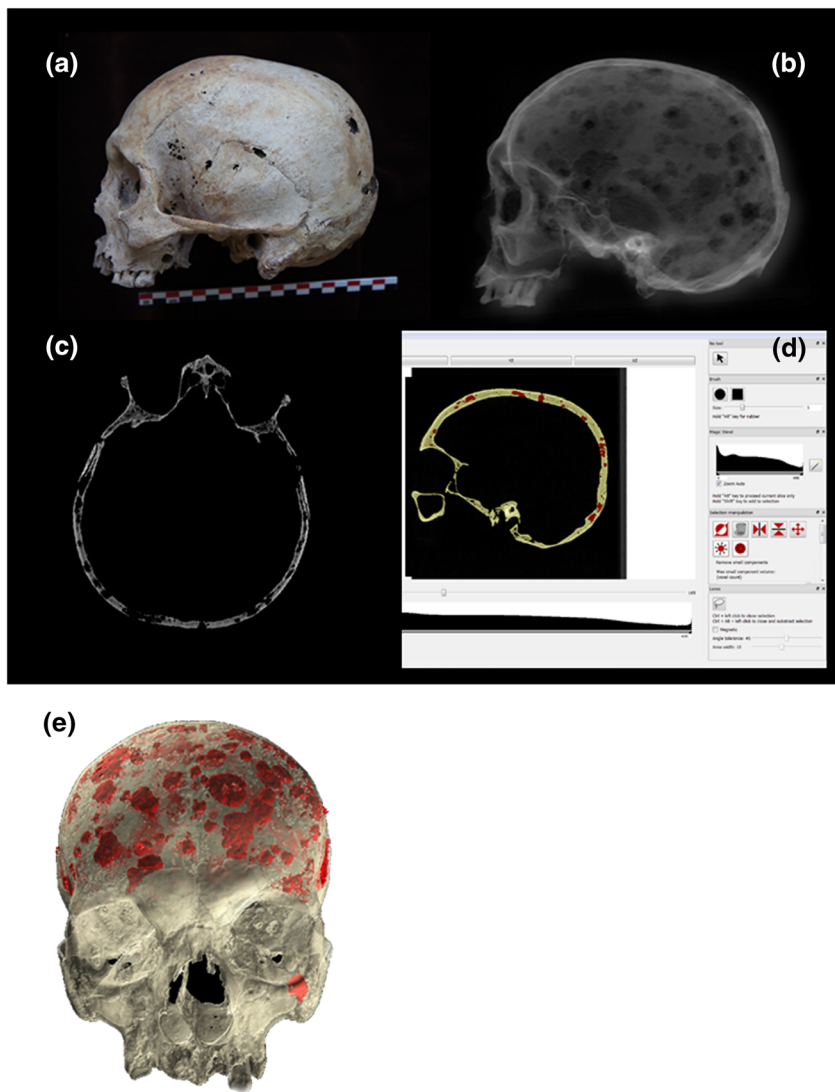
Lytic lesions on a medieval skull (Priory of Saint-Cosme, France). (a) Morphological aspect. (b) Plain X-ray lateral view showing multiple lytic lesions in favour of neoplasia (metastatic carcinoma or multiple myeloma). (c) Computed tomography (CT) scan, axial slice, showing the diploic origin of lytic lesions. (d) TIVMI software interface showing the virtual filling of each lytic lesions. (e) Three-dimensional (3D) reconstruction: besides the clear visualization of the neoplastic process, the quantification of its volume can be calculated [Colour figure can be viewed at wileyonlinelibrary.com]
